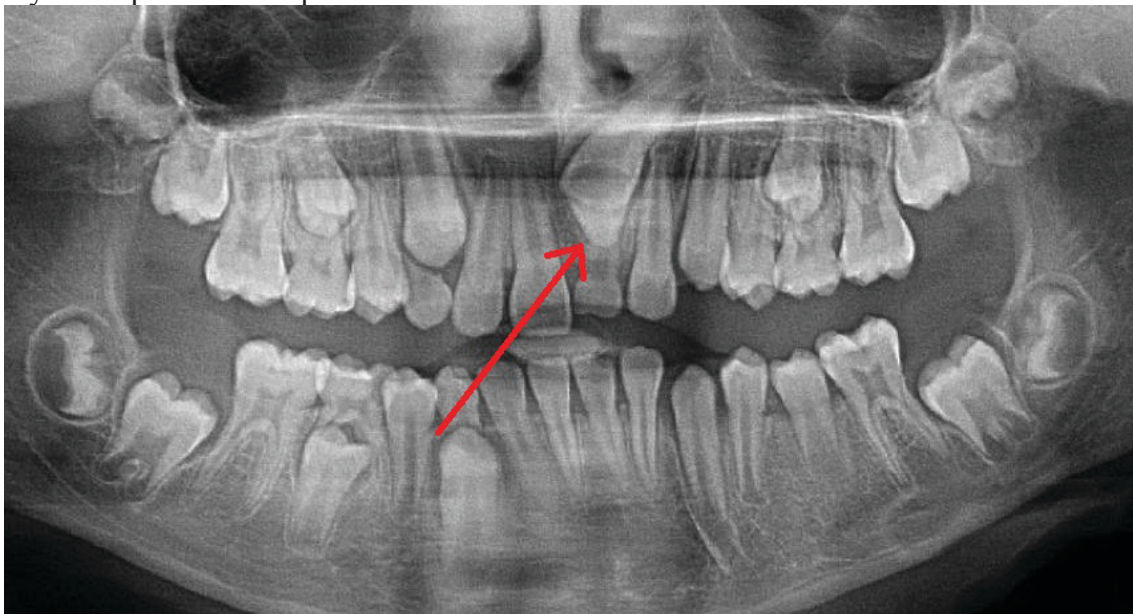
Panoramic radiograph of a patient with mesiodens resulting in delayed eruption of the central incisor (arrow).
